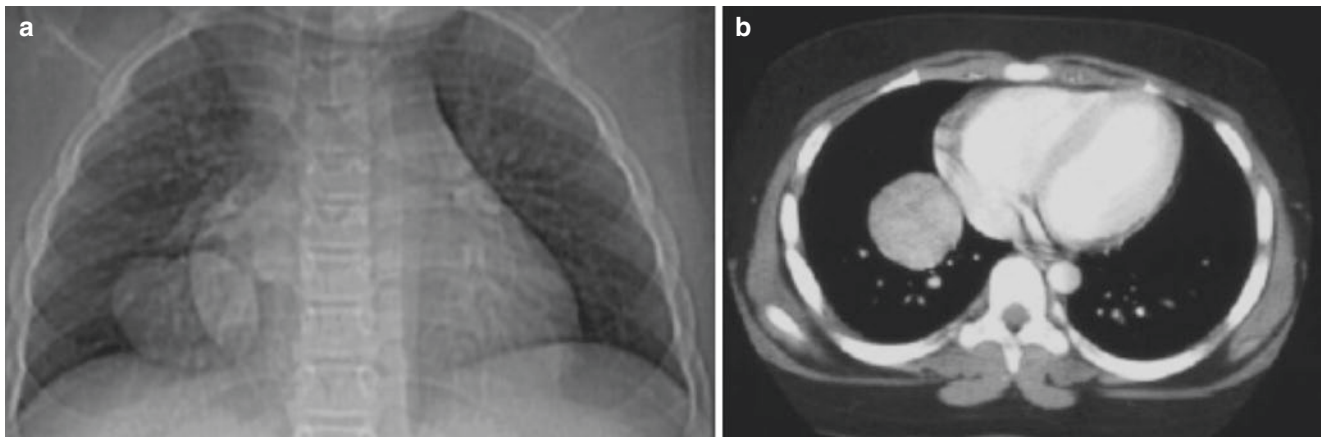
A 17-year-old boy with an inflammatory pseudotumor confirmed upon surgical resection and pathological analysis. (a) Scout and (b) axial CT images show a well-circumscribed mass located in the right lower lobe
